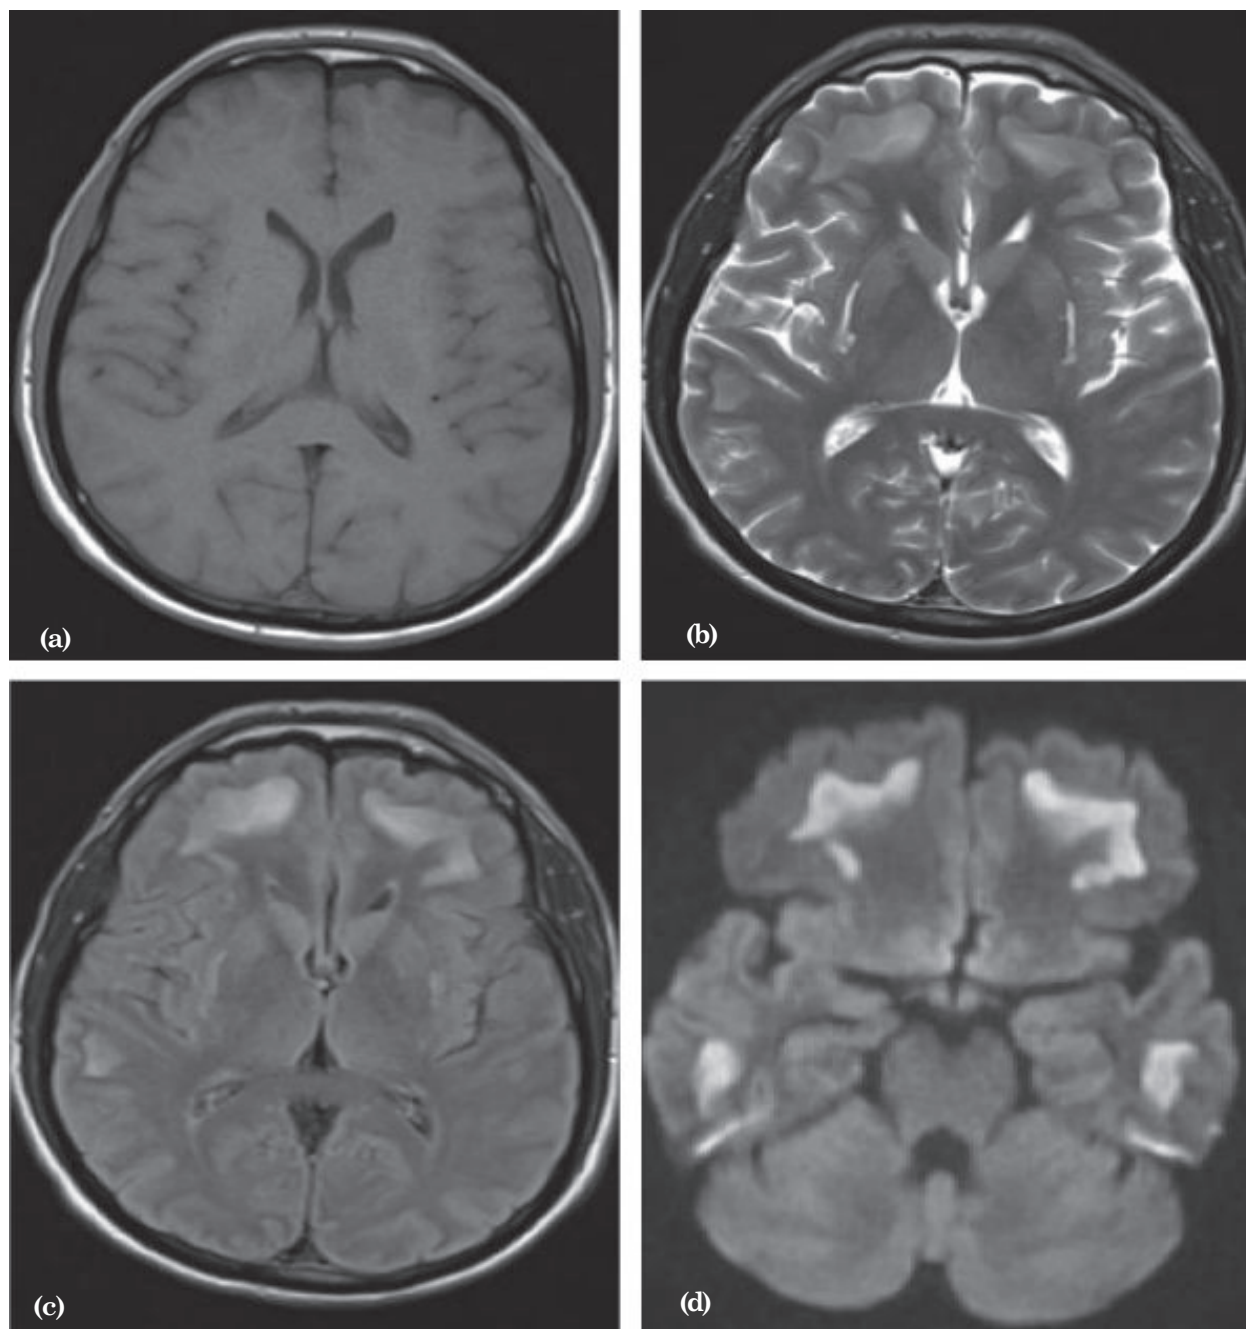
(a, b, c & d) - Axial T1, T2, FLAIR and DWI showing subcortical white matter change with putaminal early necrosis.
